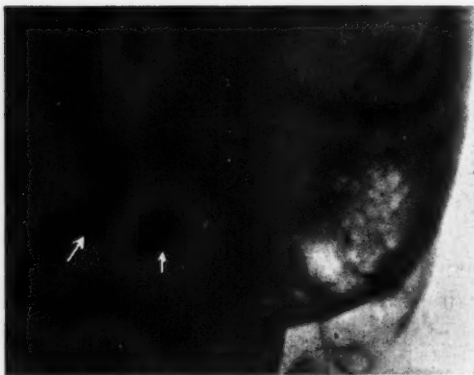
Roentgenogram of the temporal bone, after the Stenvers method. Dilatation of the carotid canal, associated with endocranial increase of pressure.
